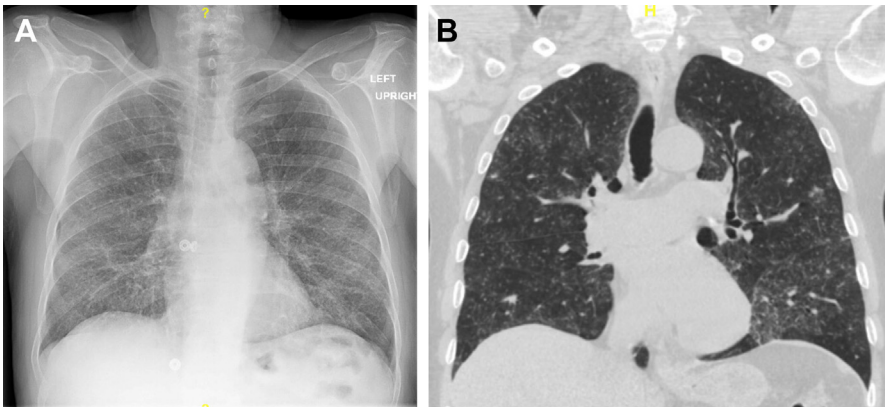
Varicella pneumonia in a 54-year-old man with multiple myeloma, relapsed following HSCT. (A) Frontal chest radiograph shows diffuse bilateral reticular and micronodular opacities. (B) Coronal chest CT confirms the diffuse solid and ground-glass micronodules in a random distribution. The distribution suggests a hematogenous component of spread of infection. (Courtesy of Shamus Moran, MD, Seattle, Washington.).
